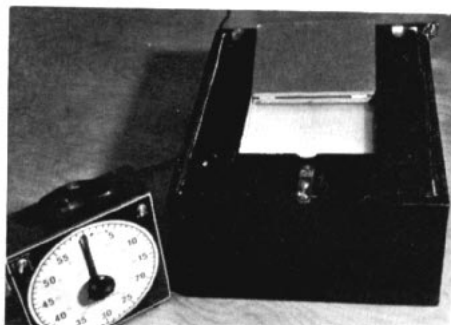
Showing the printing box used to produce the matte positives from the cephalometric radiographs.
